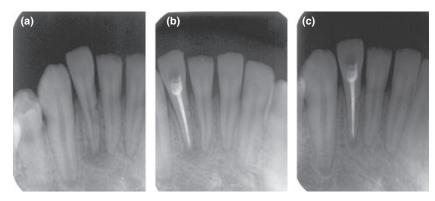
Periapical radiograph: (a) October 2009; (b) November 2009; (c) March 2010.
